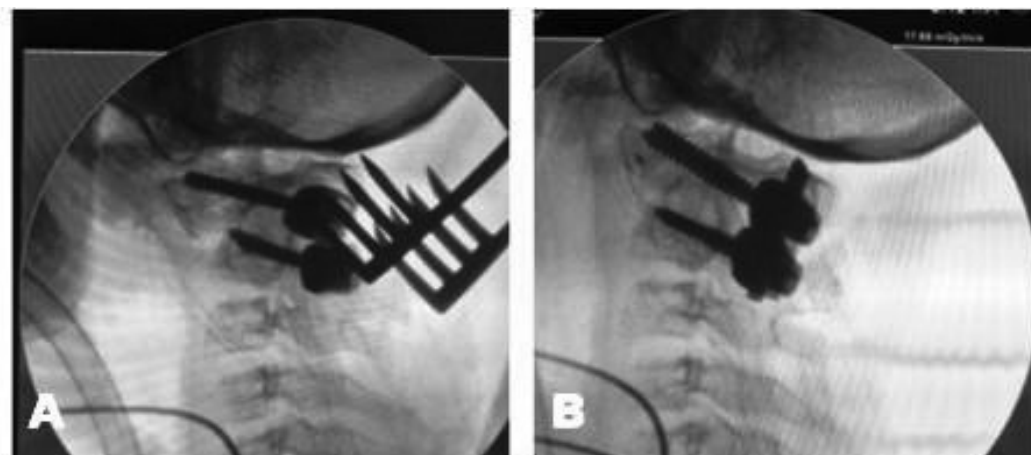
Intraoperative X-ray image of the craniocervical junction in a pediatric case with atlantoaxial subluxation showing (A) The anterior subluxation of C1 over C2 with the screws inserted and (B) reduction of C1 over C2 after rod insertion.
